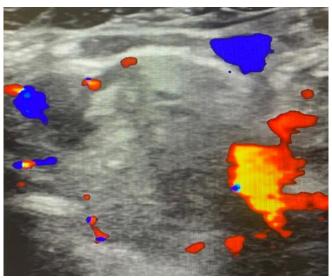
Doppler Thyroid Ultrasound
